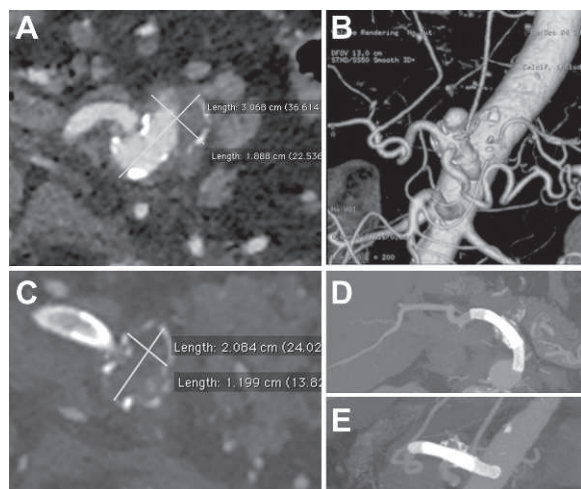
♦ (A,B) CT images show a type I A celiac trunk aneurysm (3.06×1.88 cm) with mural thrombus and 3 side branches (hepatic, splenic, and left gastric) arising from the sac. (C–E) At 1-year follow-up, the treated lesion has shrunk (2.08×1.19 cm) while the CMFM and side branches remain patent.
